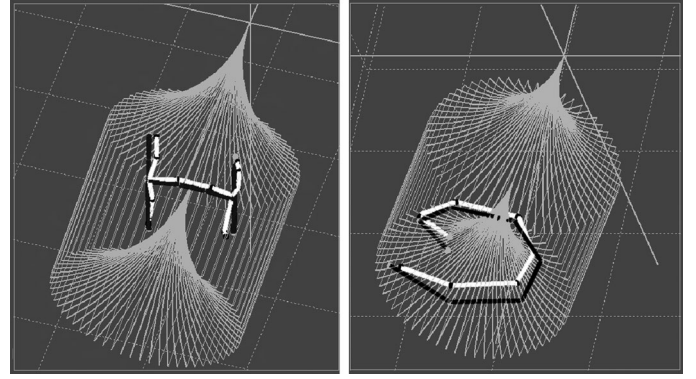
Black and white plots, visualized inside the feasible volume, are the planned and actual shapes, respectively. The letter “H” with 13 targets and helix with eight targets are consecutively reached in the gelatin. The overall error average for all 21 targets was limited to the mean of 2.41 ± 1.00 mm (standard deviation). The data were imported from CT-images.
